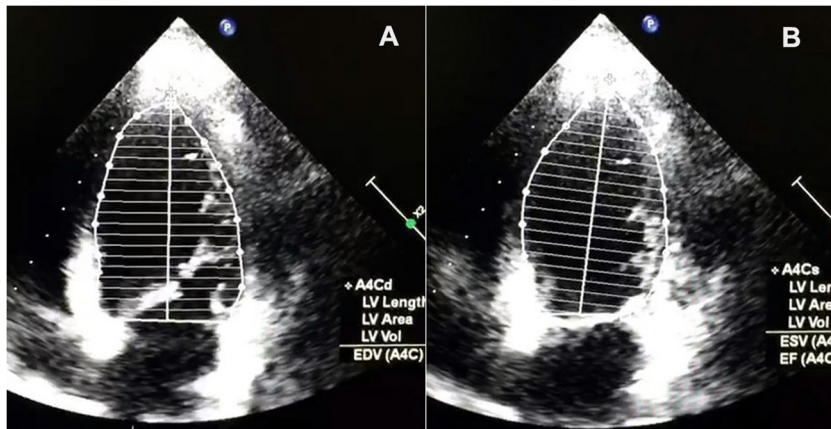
Transthoracic echocardiography apical 4 chamber view with measuring the left ventricular dimensions and using Simpson's method for determining ejection fraction which showed low ejection fraction.
